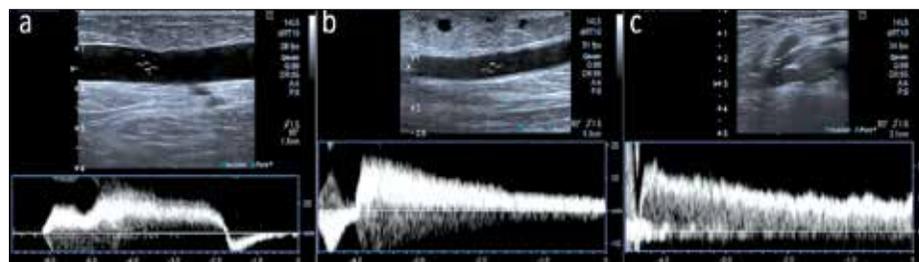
a-c. Reflux in saphenous veins. Longitudinal view and spectral Doppler imaging show significant reflux in the great saphenous vein at the level of distal thirds of the thigh following a Valsalva's maneuver (a). Spectral Doppler imaging showing significant reflux in the great saphenous vein at the level of distal thirds of the thigh (b) and in the small saphenous vein distal to the sapheno-popliteal junction in the proximal cruris, following compression of the distal parts of the calf (c)
